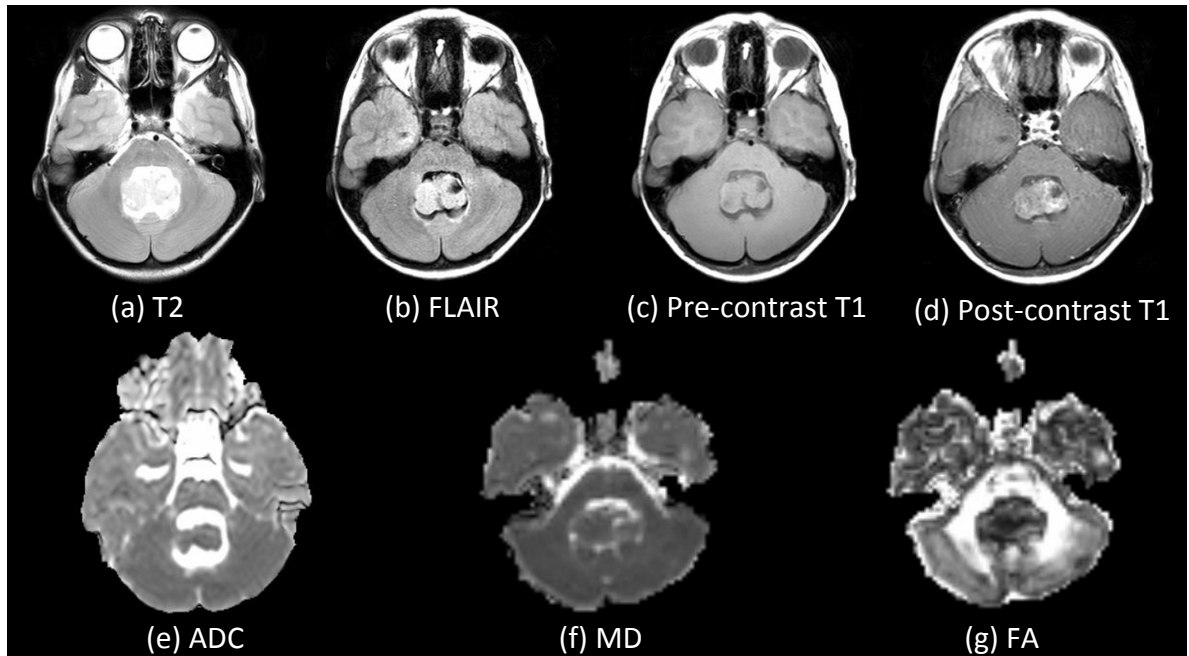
Imaging characteristics of a typical grade II ependymoma based on T2, FLAIR, pre-contrast T1, post-contrast T1, ADC, MD and FA (case EP639).
